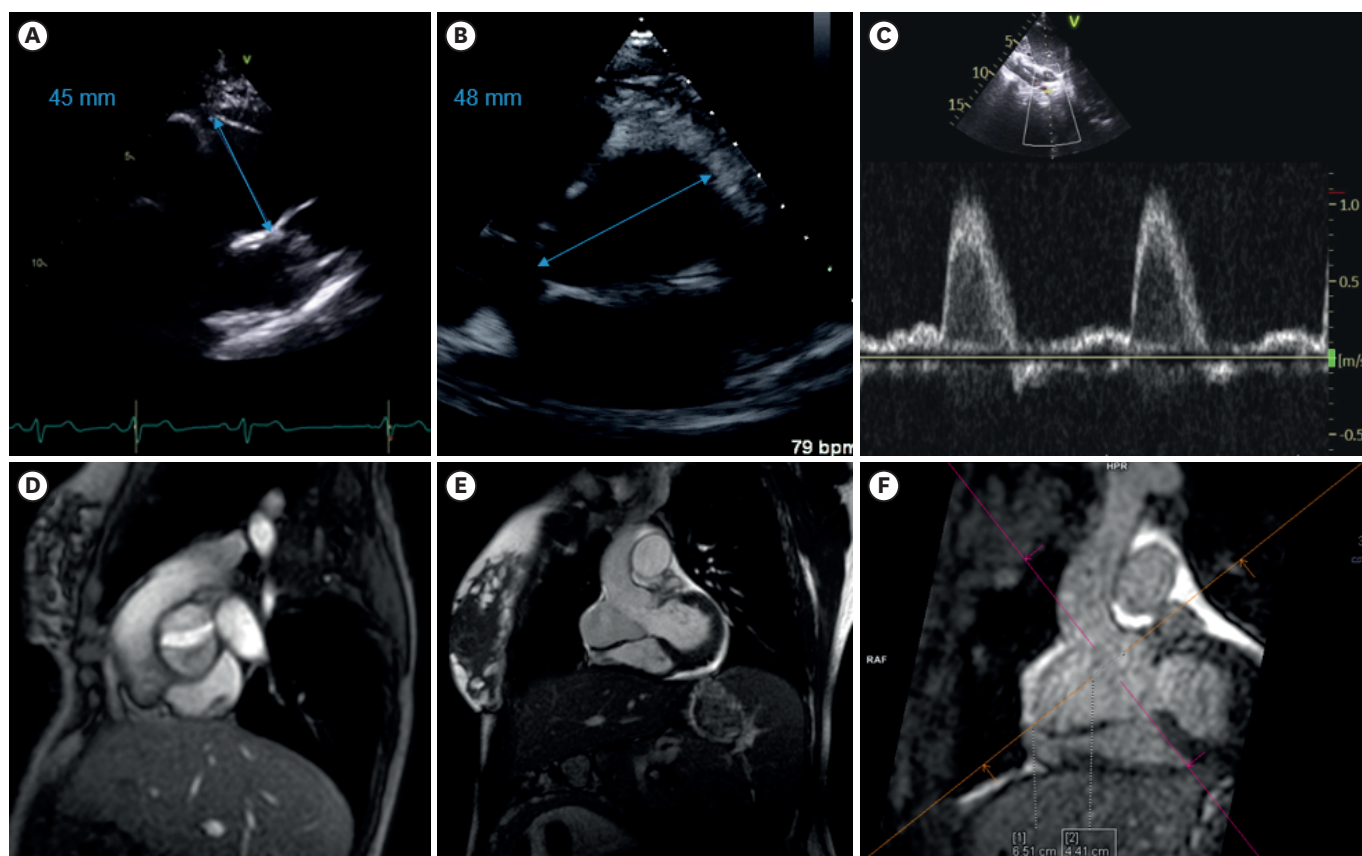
Select cardiac images of a pregnant patient with mosaic Turner syndrome. Echocardiographic parasternal long axis images revealing dilated aortic root at 45 mm (A), parasternal short axis images revealing an eccentrically dilated aortic root at 48 mm (B) and subcostal images revealing normal abdominal aortic Doppler pattern suggesting no residual coarctation (C). Magnetic resonance imaging revealing the bicuspid aortic valve (D) and eccentric aortic root dilation measuring 65 mm (E, F).
